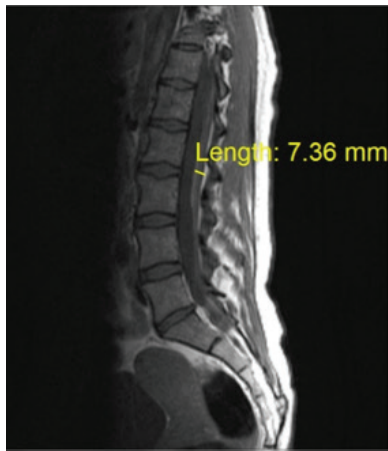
Sagittal T1-weighted LS MRI scan shows acute spinal subdural hematoma from vertebral body L1 to L4.
